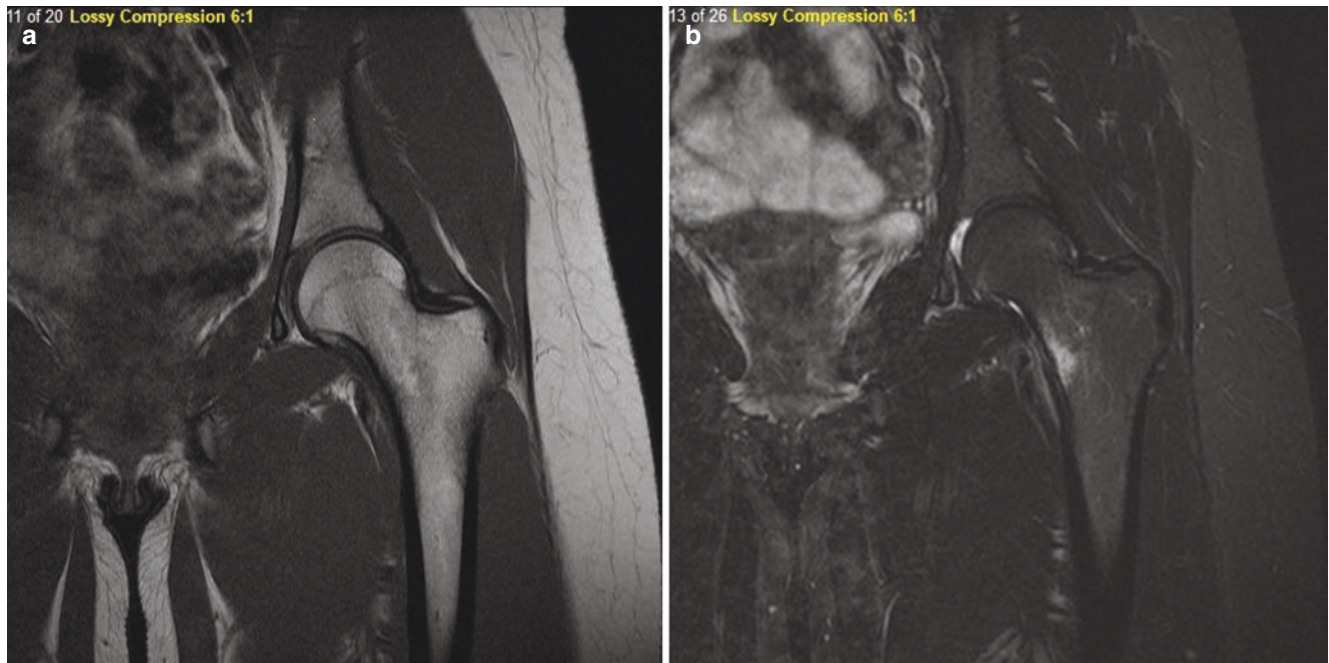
19-year-old female with a left femoral neck stress fracture as seen on (a) T1-weighted MRI and (b) STIR MRI
